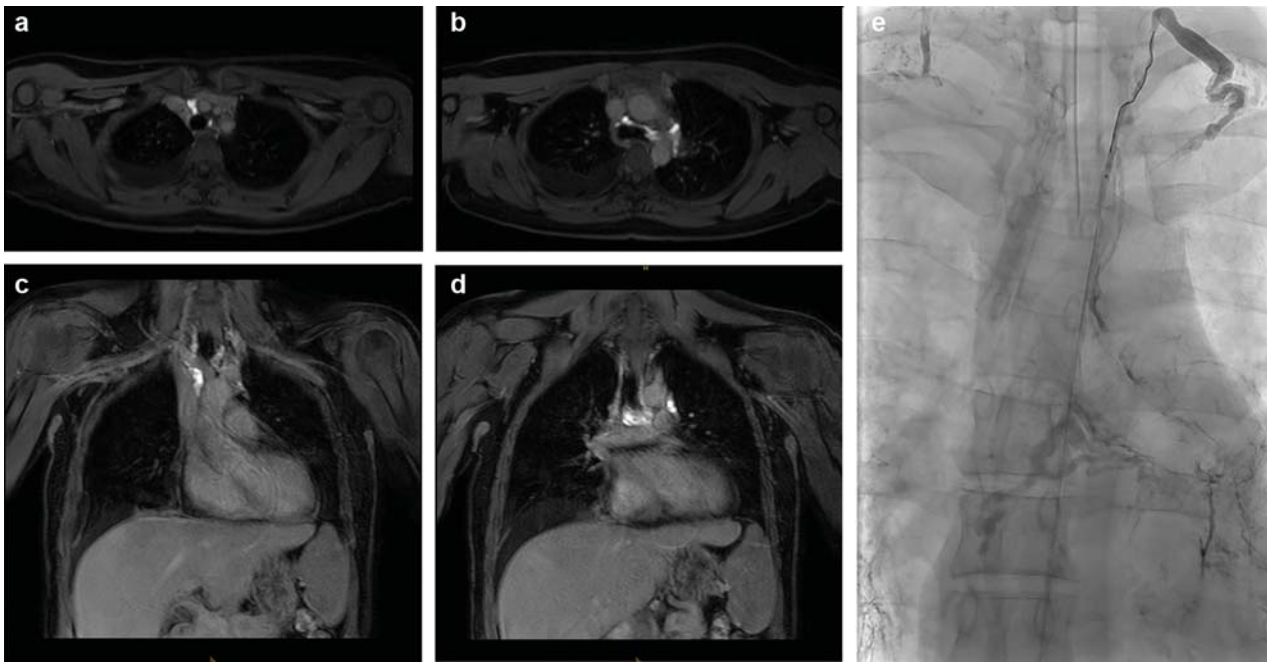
Nontraumatic chylothorax. Interstitial transpedal contrast-enhanced MRL of a 35-year-old female suffering from refractory bilateral chylothorax and chylopericardium (already drained). (a, b: axial, c, d: coronal) Normal enhancement of the thoracic duct with chylolymphatic reflux from the left venous angle into the mediastinum and pulmonary hila as the cause of chylous effusions. (e) Oily X-ray lymphangiography corroborates MRL findings. Chylous effusions ceased immediately after thoracic duct embolization.
